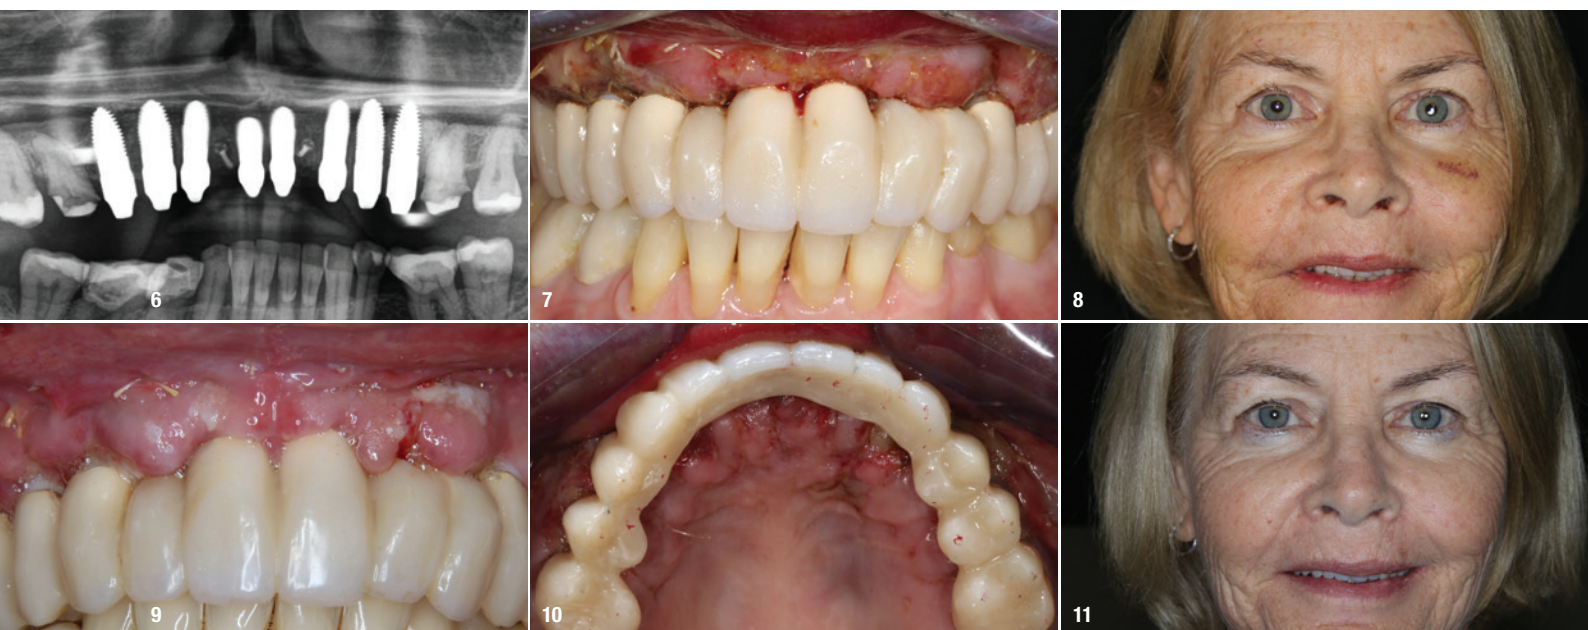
Post-op panoramic radiograph. Fig. 7: Intra-oral situation after placement of all temporaries. Fig. 8: Patient twelve days after surgery. Fig. 9: Intra-oral situation twelve days after surgery. Fig. 10: Upper jaw twelve days after surgery. Fig. 11: Patient four weeks after surgery.
